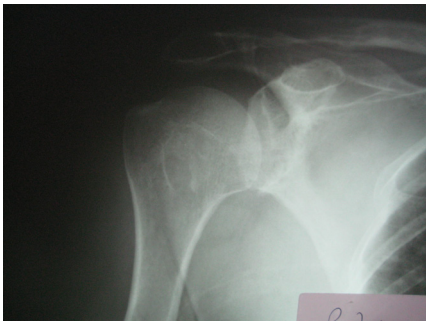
Preoperative left shoulder anteroposterior X-ray
